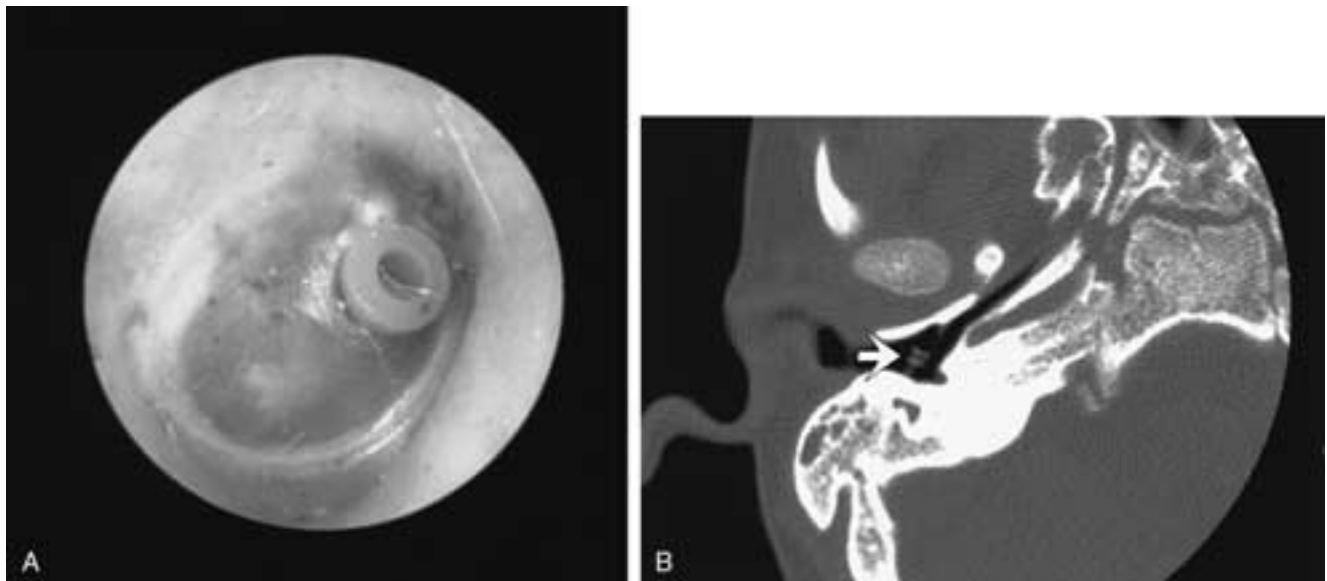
Tympanostomy tube. A, Otoscopy. A myringotomy tube is seen anterior to the malleus in the right TM. B, Axial CT (arrow).
